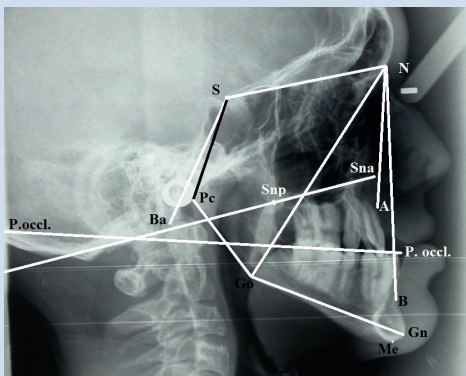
Landmarks and definitions of the cephalometric measurements: S = Sellion. Midpoint of the fossa hypophysealis (point of intersection between the maximum horizontal diameter and the maximum vertical diameter of the sella turcica); N = Nasion. Most anterior point of the frontonasal fissure.; SN = Cranial base plane; A = subspinalis. Deepest anterior point in the concavity of the anterior maxilla; B = supramental. Deepest anterior point in the concavity of the anterior mandible; Go = Gonion. Point of intersection between the line bisecting the posterior and inferior borders of the mandible and the contour of the chin; Gn = Gnation. Point of intersection between the contour of the chin and the line bisecting the inferior border of the mandible and the line passing through N and Pg; Pg = Pogonion. The most projecting point in the contour of the chin; GoGn = Mandibular plane; Oclp = Posterior occlusal point. Middle point between the mesial cusps of the upper and lower first molars; Coa = Anterior occlusal point. Middle point between the cusps of the upper and lower first pre-molar; Oclp-Coa = Occlusal plane; Me = Menton. Most inferior point of the osseous chin; ANS = Anterior nasal spine. Most anterior point of the antero-posterior profile of the upper jaw; PNS = Posterior nasal spine. Most posterior point of the bony palate defined by the pterygomaxillary fissure; ANS/PNS = Palatal plane; Ba = Basion. Most postero-inferior point of the clivus; Pc= Posterior Condylar point. The intersection of a line along the posterior border of the basal occipital bone; PcGo = Ramus Plane; SNA Sagittal position of the maxilla relative to the anterior cranial base plane SN; SNB Sagittal position of the mandible related to the anterior cranial base plane SN; ANB Reciprocal relation between the upper and lower jaw on the intermaxillary angle; ANS-PNS^GoGn Intermaxillary angle; SN^ANS-PNS Palatal plane angle; SN^P.occl. Angle between cranial and occlusal planes; SN^GoGn Cranio-mandibular angle; SN^SBa Cranial base flexure angle; SN^SPc Sellar angle; SPc^PcGo Articular angle; GoPc^GoGn Gonial angle; GoPc^GoN Upper gonial angle; GoN^GoGn Lower gonial angle; WITS Distance between the orthogonal projection of A and B points on the occlusal plane; (Sna-Me)/(NMe) Ratio of the lower facial height to the total face height; (SGo)/(NMe) Ratio of the posterior facial height to the anterior facial height; FIG. 3B panoramic x-ray of an 8 years old patient with GGS and with evident mandibular keratocyst that involves multiple teeth.
